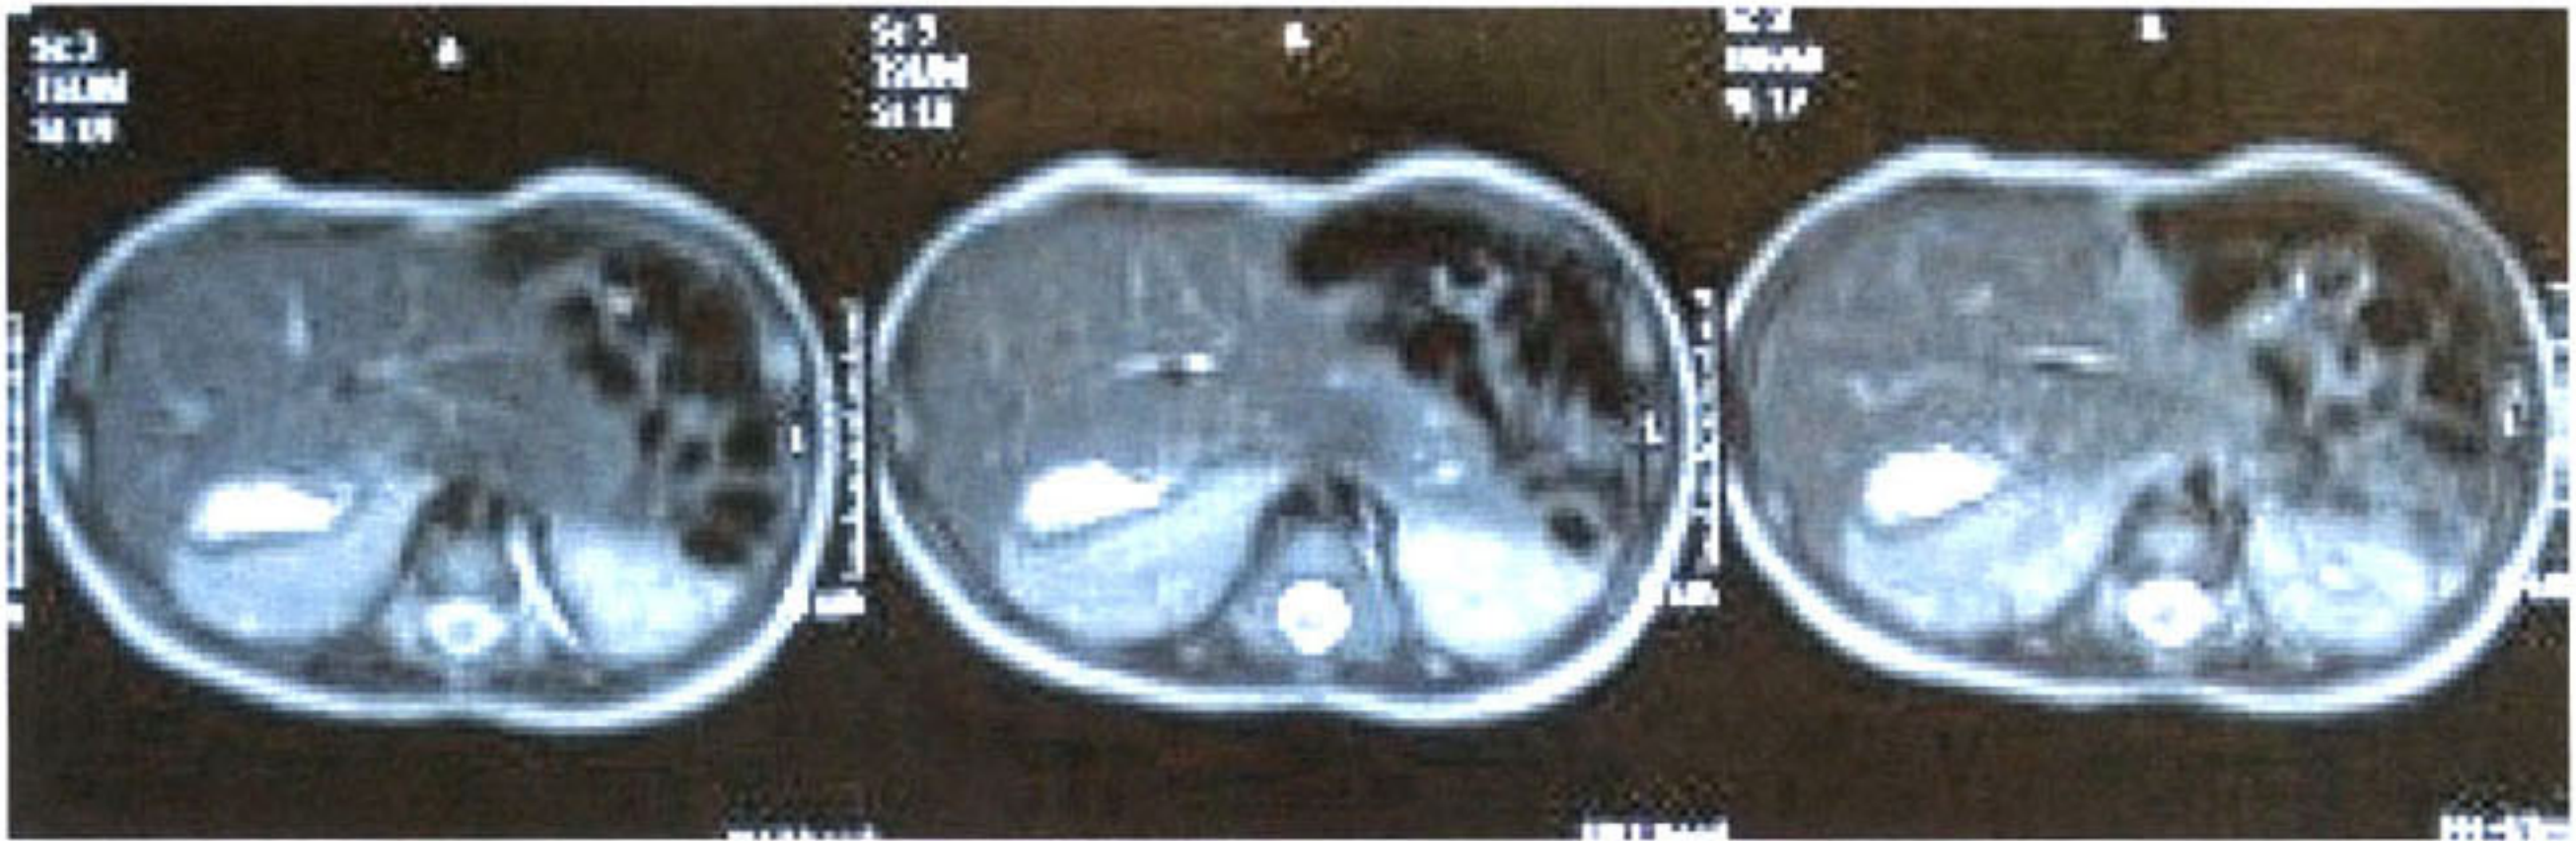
CT-Scan Showing Liver, Stomach and Spleen located on the Right Side of the Abdomen.
